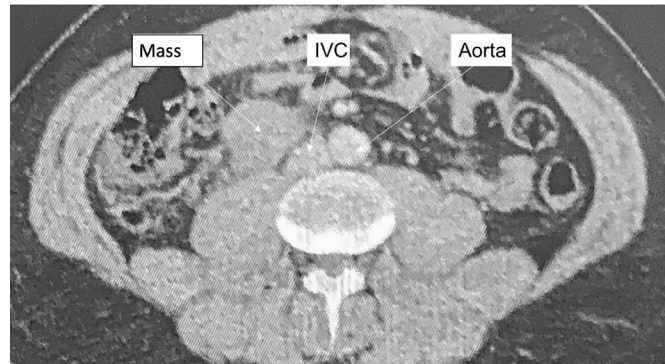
Sagittal plane of a CT scan showing a retro-peritoneal and laterocaval tumor.
